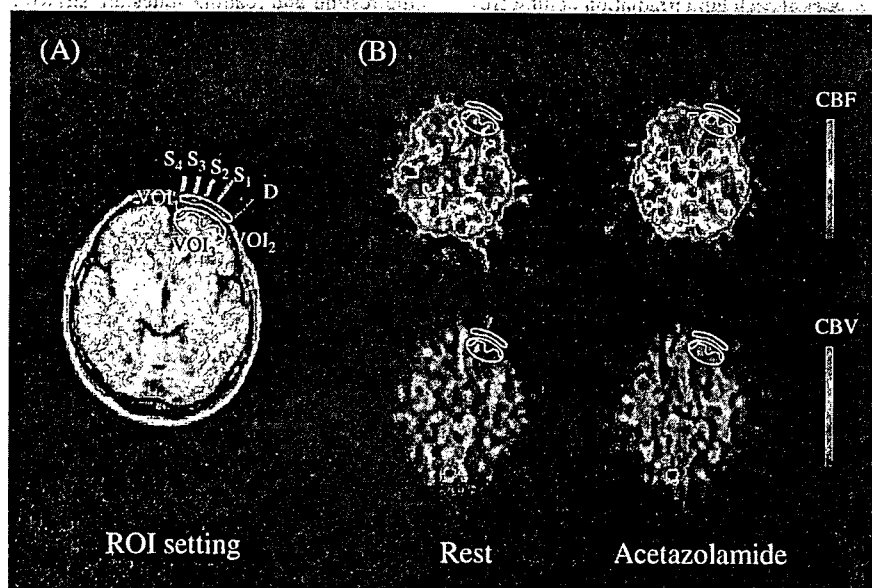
Fiber and VOI positions setting on MRI image and PET images. (A) Fiber markers appear on left forehead. S_{1-4} and D are corresponding to irradiation fibers and a detection fiber, respectively. Optode spacings of S_1 - D : 2 cm, S_2 - D : 3 cm, S_3 - D : 4 cm, S_4 - D : 5 cm were set. The four PET VOIs were set as follows. VOI_1 : extracerebral tissue, VOI_2 : gray matter region, VOI_3 : gray matter and white matter regions. (B) Images of typical measurements (41 years old; male) of PET CBF (upper) and PET CBV (lower) in the resting (left) and loading (right) state.
